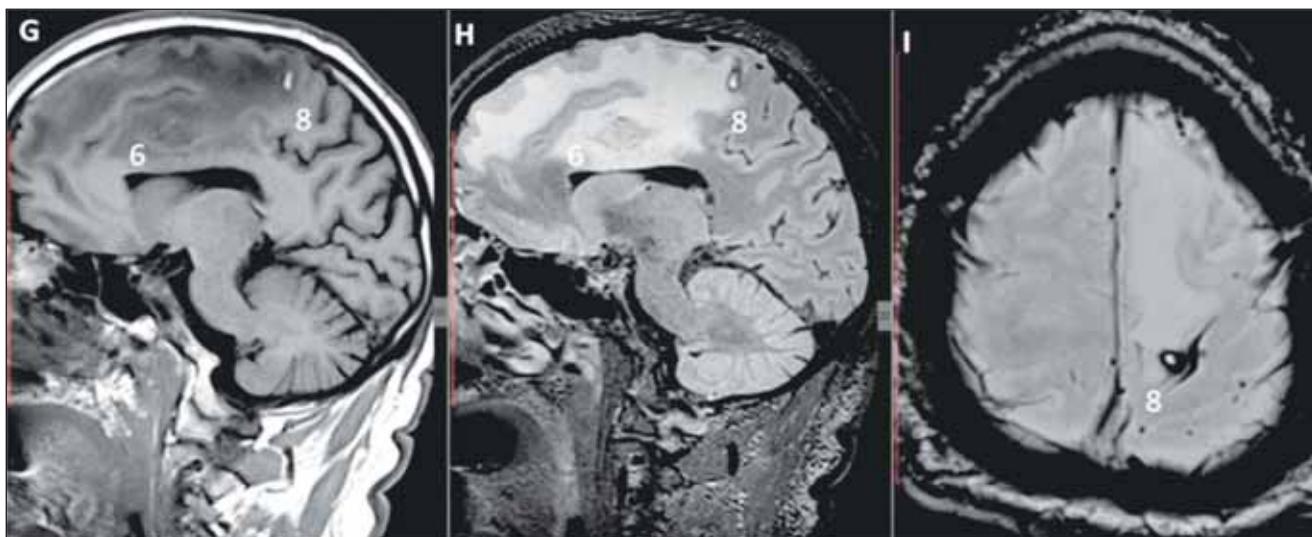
G – T1, H – FLAIR, I – SWI. Lesion no. 8 is noticed in the left parietal lobe as a hyperintense T1/FLAIR/SWI lesion with a hypointense T1/FLAIR/SWI rim. Lesion no. 6 appears in heterogeneous signal on T1/FLAIR.
